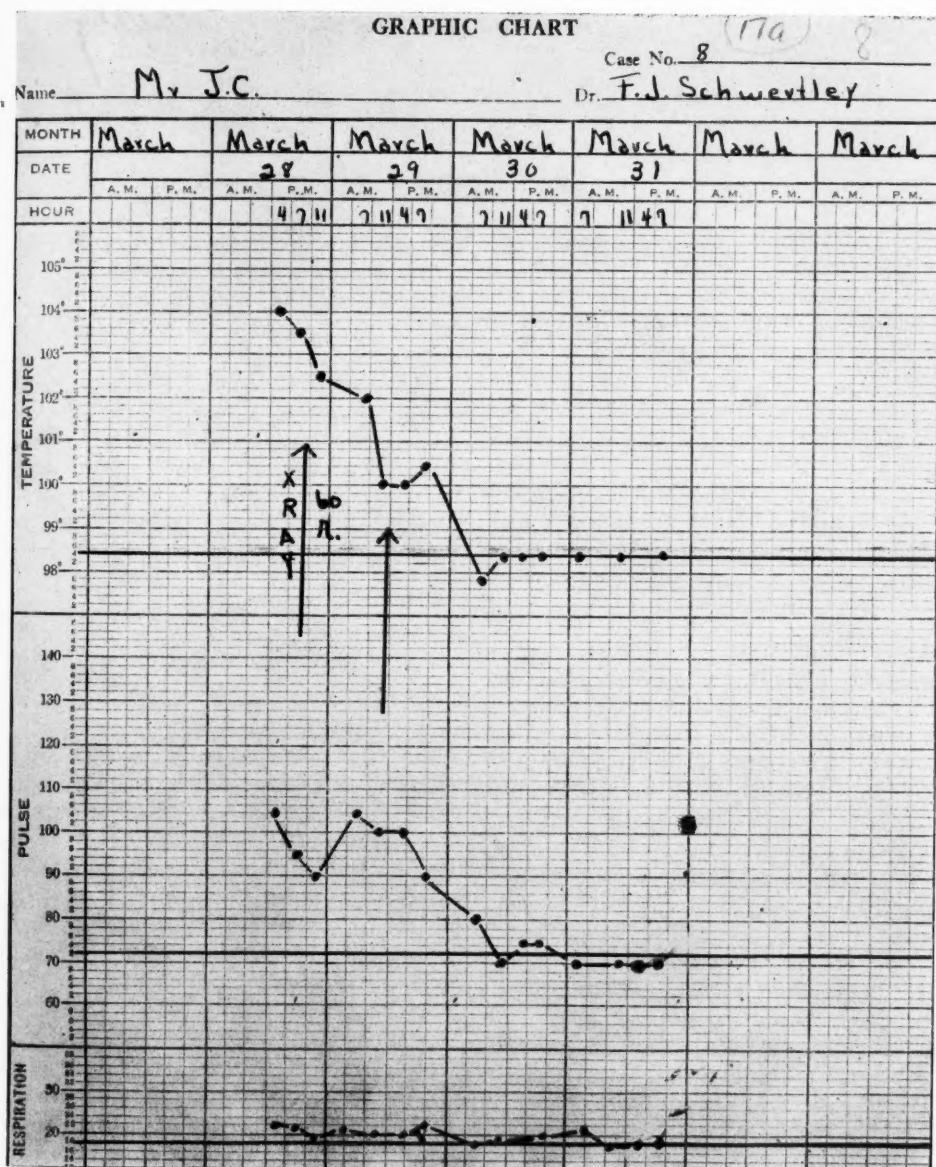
Case 8. Diagnosis: cellulitis of foot, penetrating wound. X-ray technic: kv. 100; ma. 5; distance 40 cm.; filter 3 mm. Al; r units, 60 per treatment; port, foot and ankle area, one surface; result, excellent.
